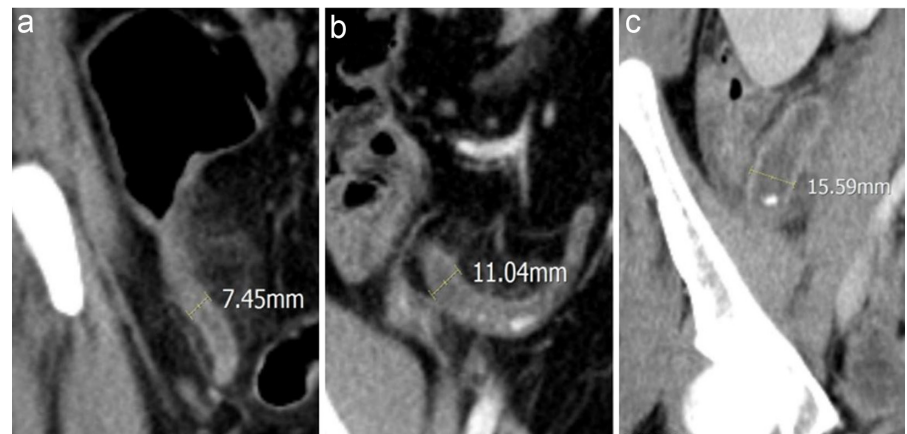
Example of the appendix diameter. On contrast-enhanced abdominal CT scans, the diameter of the appendix lumen was measured and it was graded as 1 (≤ 9 mm) (a), 2 (10-12 mm) (b), and 3 (≥ 13 mm) (c).
